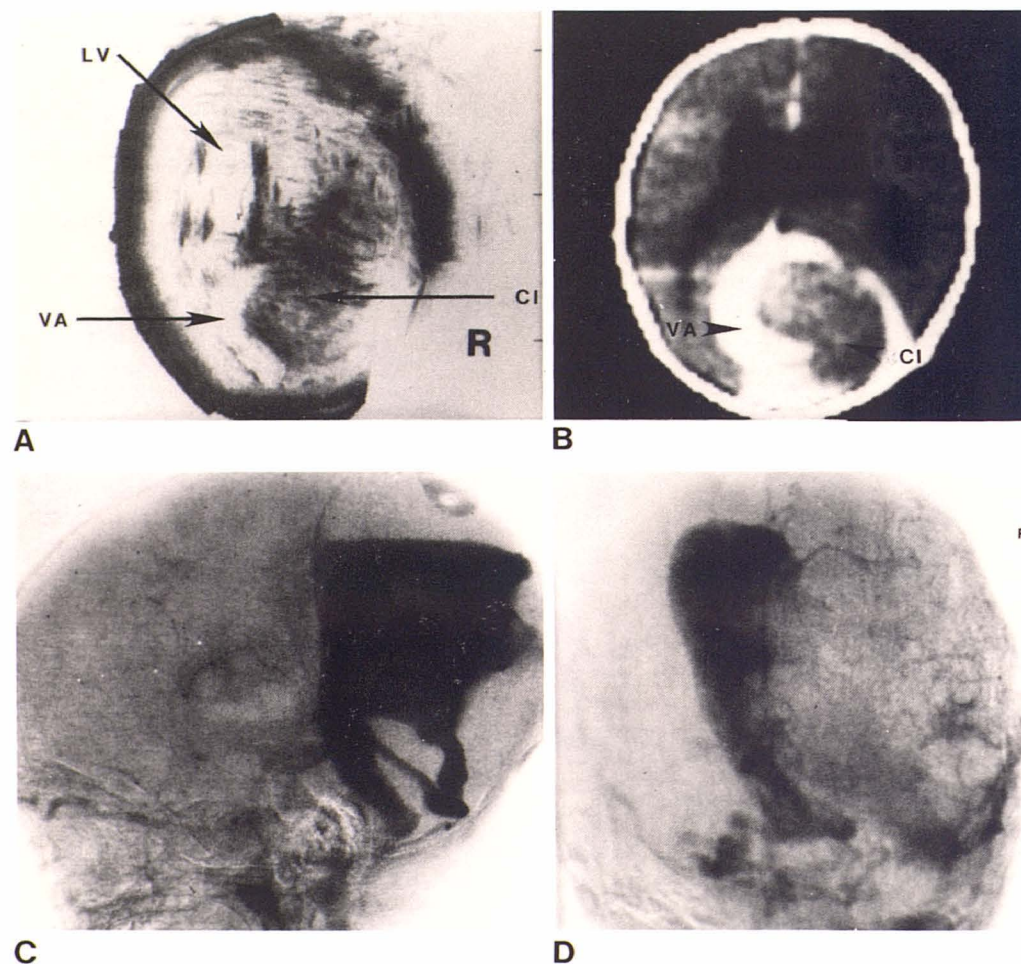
Case 11. Arteriovenous malformation in 2-month-old infant with enlarging head, lethargy, and vomiting. Axial ultrasound scan (A) and corresponding CT scan (B). Moderate enlargement of the lateral ventricles (LV). Large echogenic mass (CI) in occipital area with surrounding semicircular anechoic zone (VA). CT findings were similar with semicircular structure enhancing after contrast material injection, suggesting vascular structure. C and D, Angiograms. Large, complex dural venous aneurysm containing blood clot in region of straight sinus and posterior falx cerebri.
